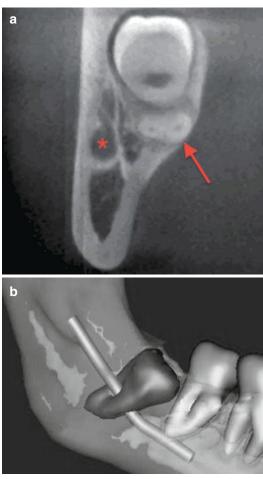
(a) CBCT image in the mandibular third molar region showing buccal displacement of the IAC (*asterisk*) and thinning of the lingual plate near the third molar roots (*arrow*). Neither the IAN nor LN is visible on these images. (b) Three-dimensional CBCT reconstruction showing position the course of the inferior alveolar canal between the impacted third molar roots. This is merely a reconstruction of the inferior alveolar canal without any information about the IAN itself
